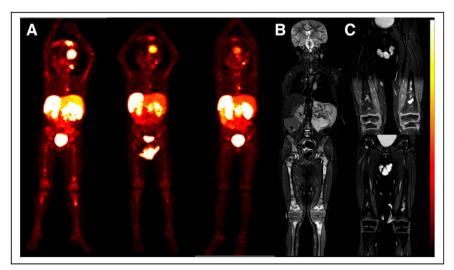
(A) Resolution of bone marrow disease on ⁶⁸Ga-DOTATATE PET/CT (from left to right: initial staging, 2 mo, and 6 mo). (B and C) Short-tau inversion recovery MRI still showing changes at 6 mo (false-positive MRI) (initial staging [B], 2 mo [C top], and 6 mo [C bottom]).
